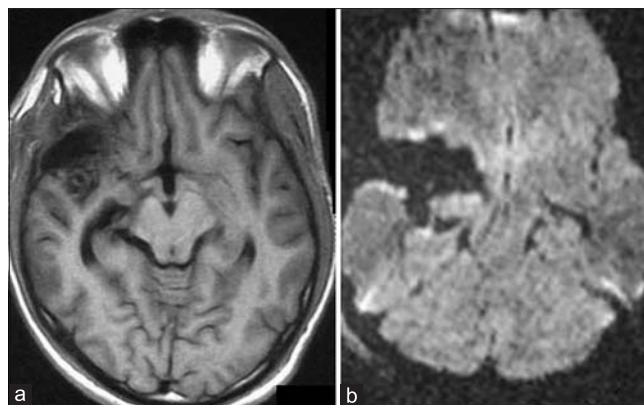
Postoperative images. (a) Axial T1-weighted image showing excision of the epidermoid with no compression on the midbrain. (b) Diffusion-weighted image showing excision of the epidermoid
